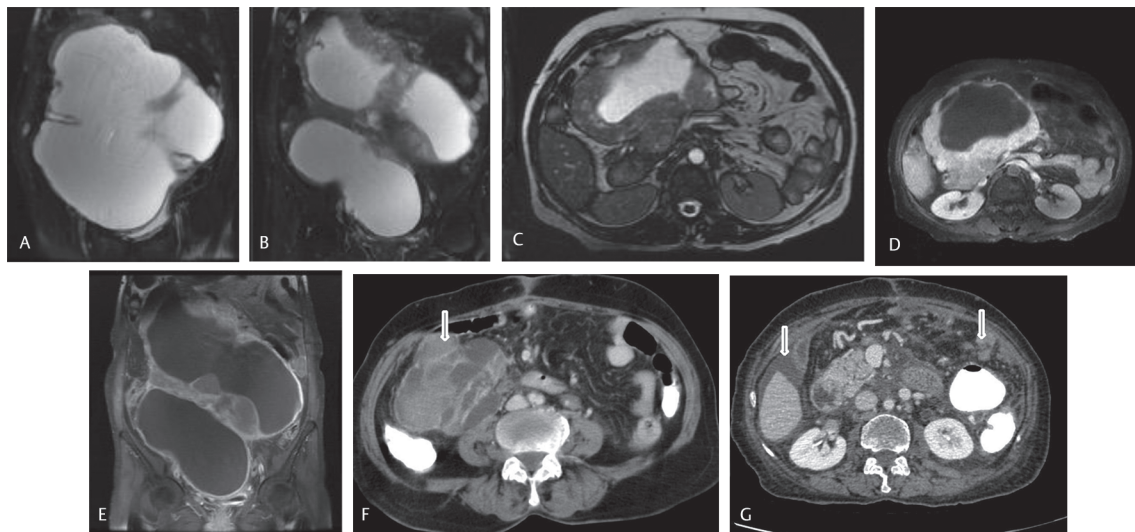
Correlative MRI scan—Coronal T2WI images (A, B) of a known case of neurofibromatosis type I (NF1), showing large complex solid cystic lesion filling almost the whole abdomen. Axial FIESTA image (C) shows the superior end of the lesion indenting the 3rd segment of duodenum. Central cystic and peripheral solid components of lesion appreciable. Postcontrast axial (D) and coronal (E) T1W images show moderate to marked enhancement of the peripheral solid components. Postsurgical, follow-up contrast-enhanced CT axial images (F, G) after 6 months show recurrence in the right iliac fossa (solid cystic mass) along with ascites and multiple omental deposits (white arrows). High risk tumor with predominant cystic changes and size > 20 cm and mitotic index (MI) $> 5/50$ HPF arising from duodenum with recurrence on follow-up.
